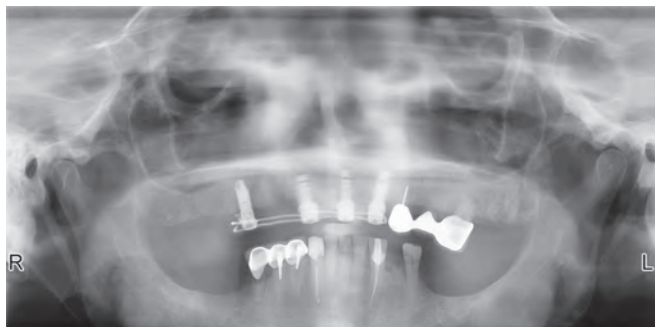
Final panoramic X-ray with fixed implant-supported provisional bridge in place
